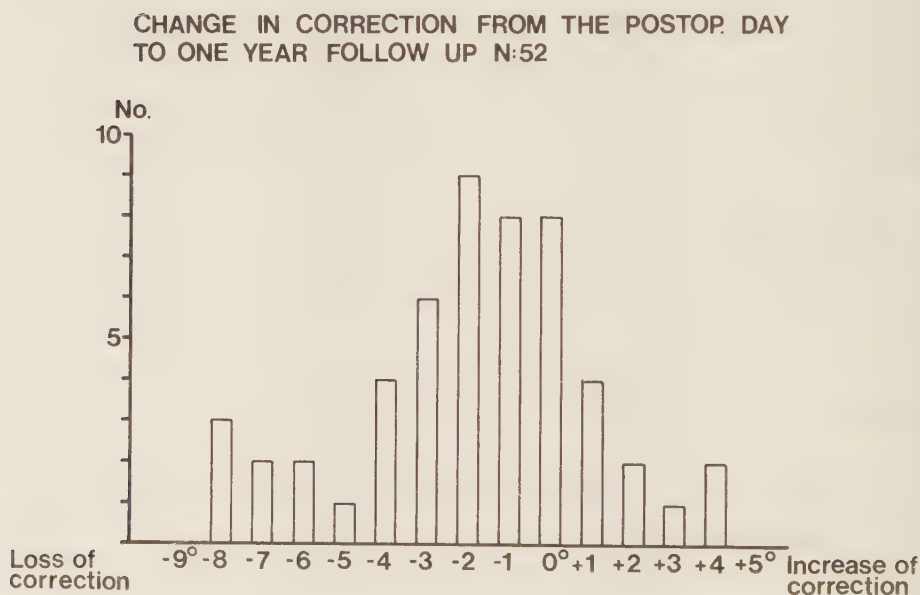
Loss of correction during the first year. The correction was measured on ordinary frontal tibial radiographs as the change in the angle between the articular plane and the anatomic axis of the tibia. The angle was measured at the immediate postoperative control and at the one year follow-up.
